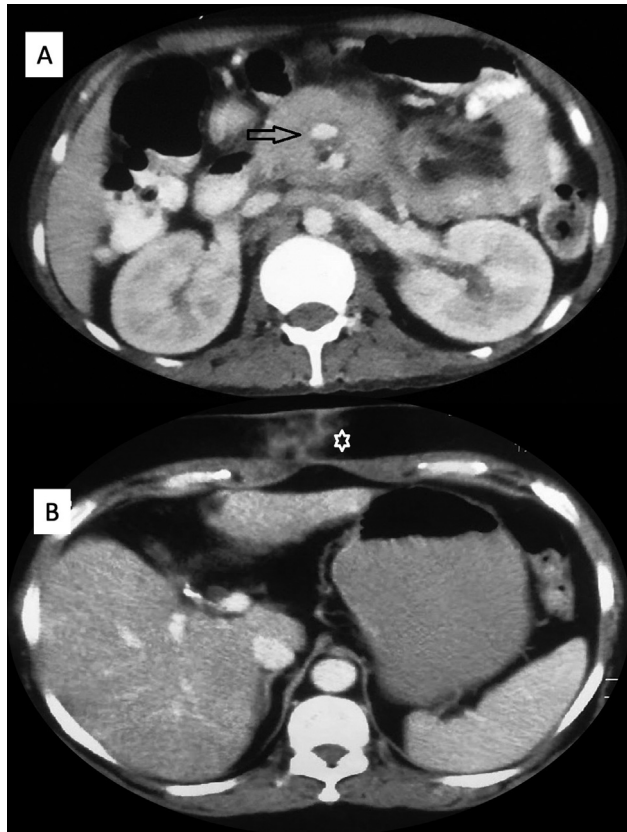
(A) Computed tomography showing a lymph nodal mass encasing superior mesenteric artery (arrow). (B) Inflammatory changes at the port site (asterisk).
